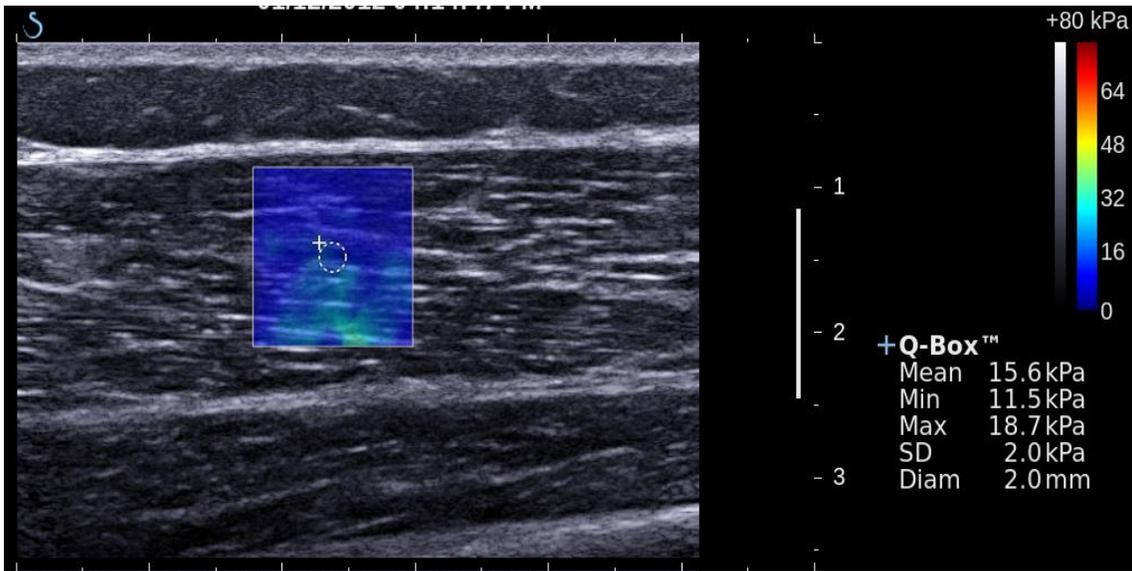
The colored box above is the area receiving the pulsed ultrasound. The color variation within the box indicates areas of differing stiffness. The circle in the middle of the box is the area from which the stiffness measurement will be taken. On the right side of the screen the mean stiffness is indicated, as well as the min and max stiffness and the standard deviation within the circular region of interest.
